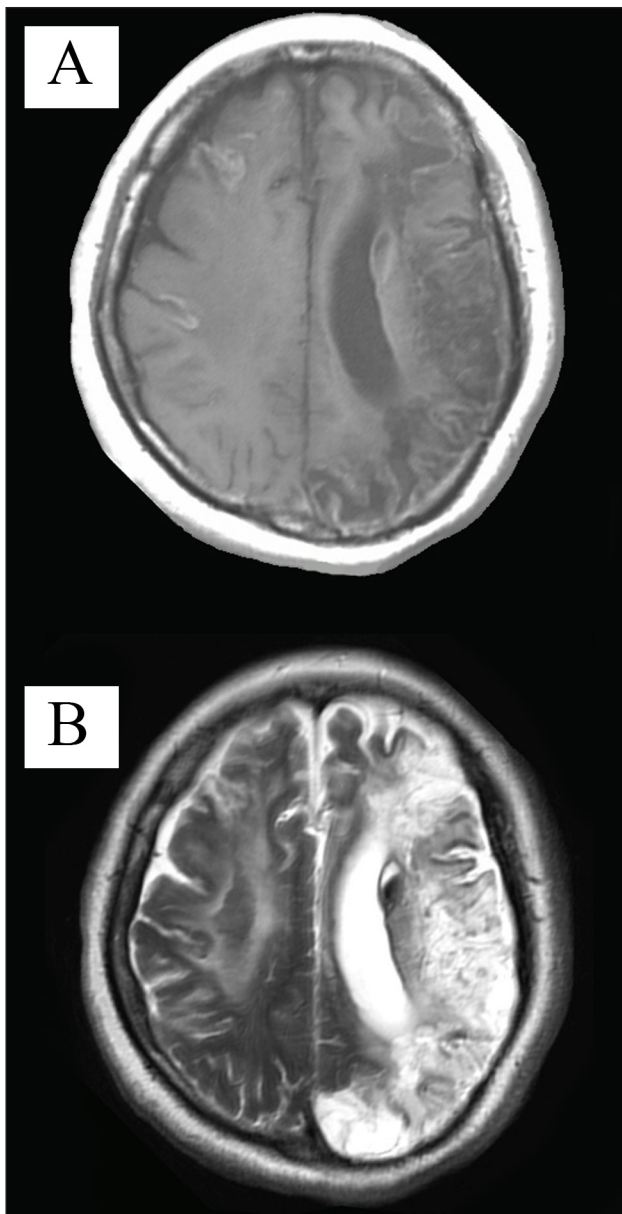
Axial T1-weighted magnetic resonance (A) and T2-weighted magnetic resonance (B) on May 28 2010, revealing bilateral cortical hemorrhage with subcortical extension and isointense signal of the superior sagittal sinus on both sequences
